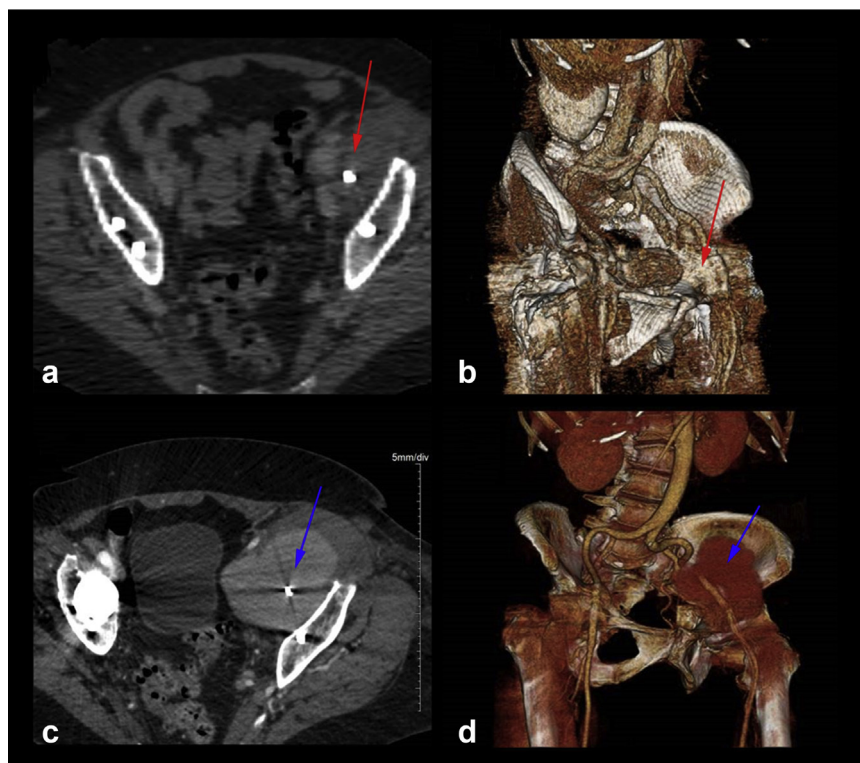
(a) Axial cut of noncontrast CT demonstrating initial left external iliac PSA that was underappreciated. Red arrow shows the location of the screw in the small PSA. (b) Three-dimensional reconstruction of the same noncontrast CT scan demonstrating mass effect in the area of PSA confused with myositis. (c) Axial image of CT angiogram done 2 months later showing large PSA with screw in the center (blue arrow). (d) Three-dimensional reconstruction of the CT angiogram demonstrating the large PSA and its mass effect on the EIA compared to image B.
